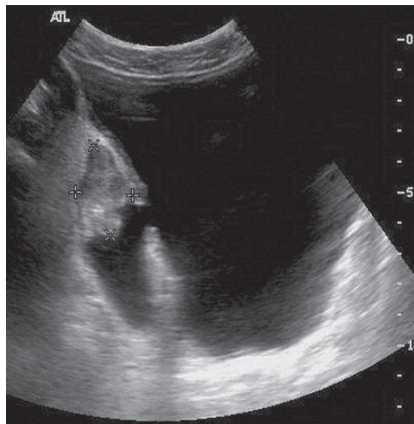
Ultrasound picture of neoplasm in bladder diverticulum
